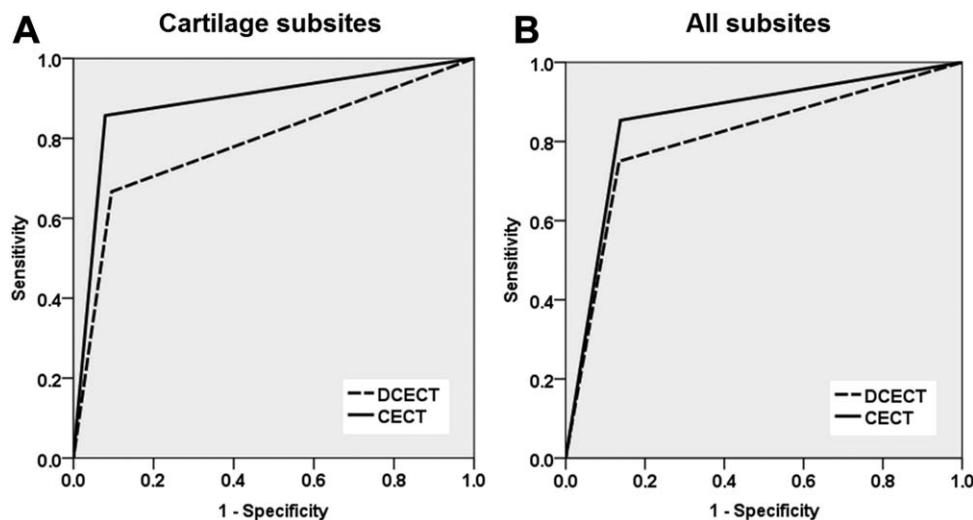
Likelihood ratio graphs of (A) cartilage subsites, and (B) all subsites. From these graphs, it can be easily appreciated that CECT appears to have overall better diagnostic properties than DCECT. CECT = contrast-enhanced computed tomography; DCECT = dynamic contrast-enhanced computed tomography.
